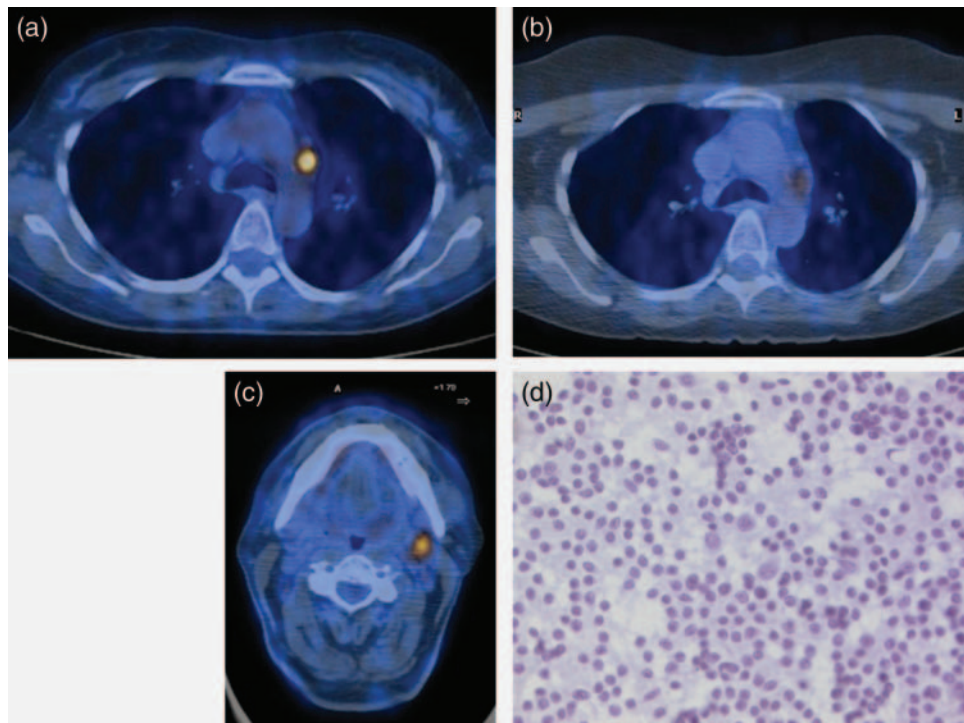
A 61-year-old man with a large-cell carcinoma of the left upper lobe and ipsilateral mediastinal lymph node invasion. (a) Axial PET/CT scan showed the high FDG activity within the ipsilateral mediastinal lymph node. (b) Restaging axial PET/CT scan demonstrated the partial response of the mediastinal lymph node after induction therapy. (c) Restaging axial PET/CT scan revealed the new solitary PET-positive lesion in the cervical lymph node. (d) Cytology after fine-needle puncture revealed a reactive lymph node.
